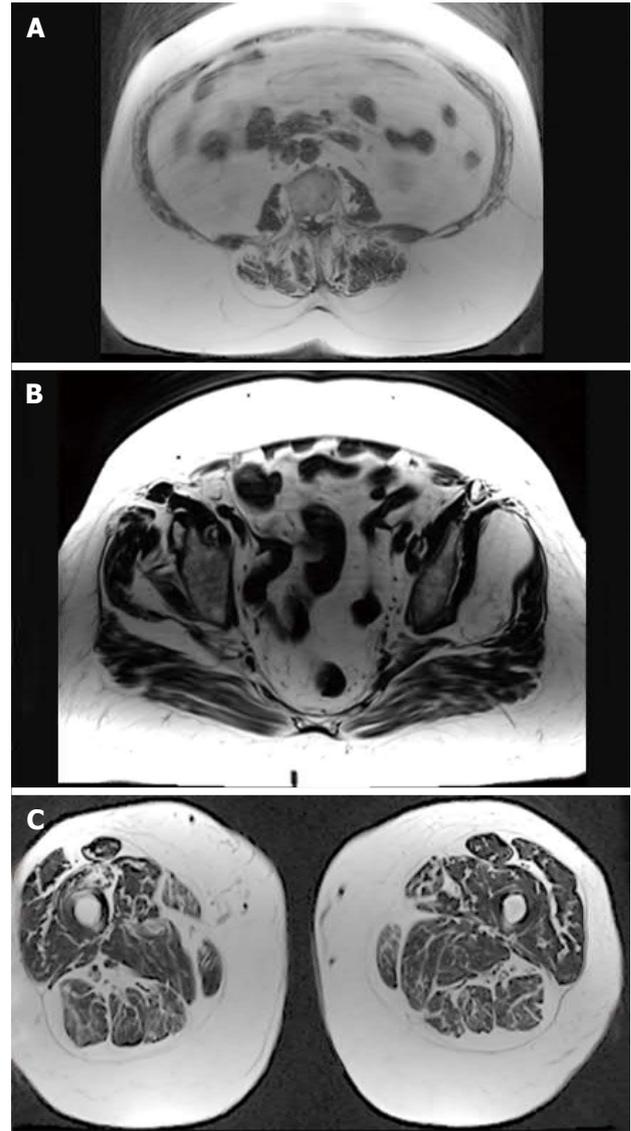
Magnetic resonance imaging samples (A: Lumbar area; B: Pelvis area; C: Limb area) of an 80-year-old female with a body mass index of 31 kg/m². This patient presents a degenerative scoliosis with a thoraco-lumbar Cobb angle of 32°, a hyperkyphosis of the thoracic spine (thoracic kyphosis = 63°) and a global sagittal malalignment (sagittal vertical axis = 11 cm). The analysis of the muscle quality revealed an 28.8% of fat infiltration on average.
